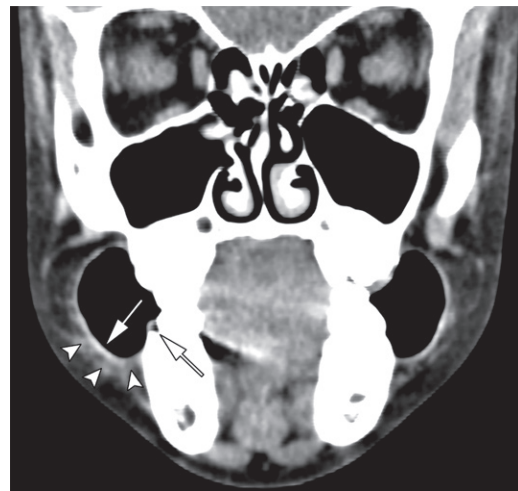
Puffed cheek technique. Coronal non-enhanced CT image (soft-tissue window) shows the oral cavity distended by air, with mucosal thickening (arrows) and subcutaneous edema (arrowheads), which could be difficult to depict without the technique.
